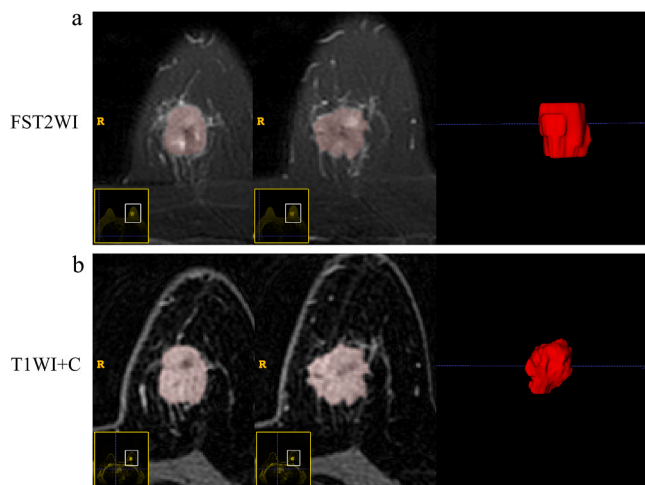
Examples of manual lesion segmentation in a patient with endometrial cancer. Axial fat saturation T2-weighted imaging (FST2WI) with manually segmented regions of IDC (a) and axial contrast-enhanced T1-weighted imaging (T1WI+C) (b).
